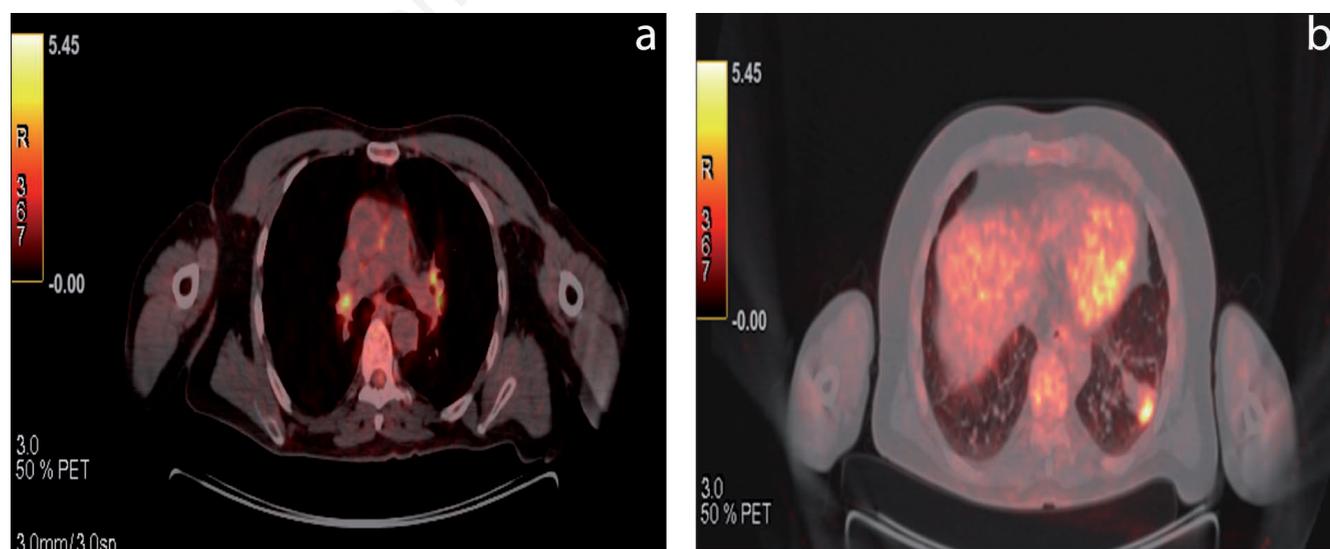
Axial (a) and coronal (b) ^{18}F -FDG PET/CT fusion image revealing high FDG uptake in the left upper division bronchus and in the left lower lobe laterobasal segment nodules.
